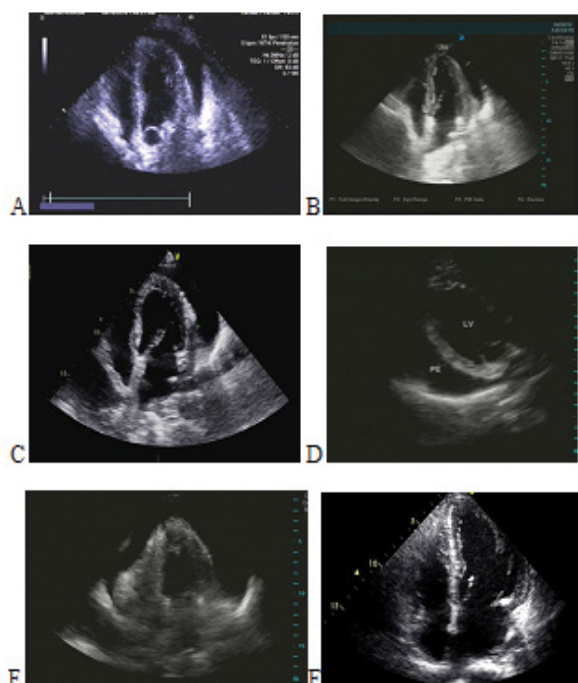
(A) Echocardiography indicated less pericardial effusion before nivolumab administration; (B) A small amount of pericardial effusion is detected after 1 cycles of nivolumab administration; (C) Mass pericardial effusion after 3 cycles of nivolumab administration; (D) shows Medium pericardial effusion 2 months after nivolumab administration; (E) shows Medium pericardial effusion 3 months after nivolumab administration; (F) Echocardiography shows no separate liquid region in pericardial cavity 4 months after therapy.
